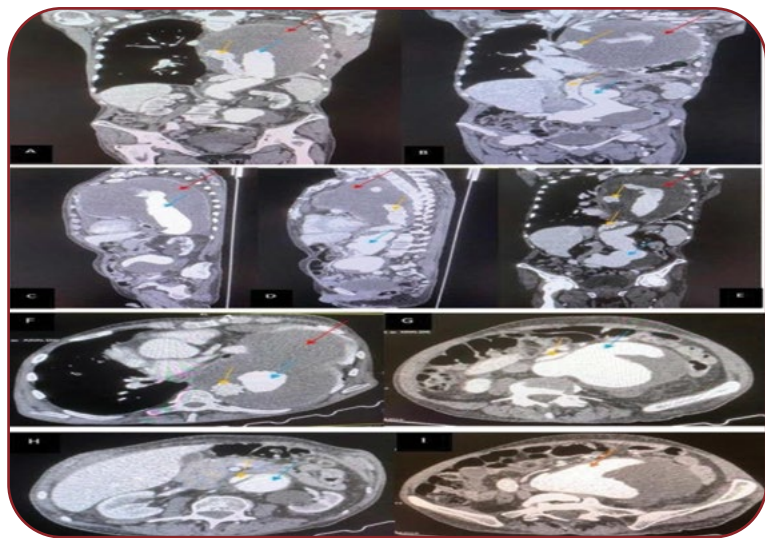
Angio CT aorta: ascending, descending and abdominal aorta – coronary plane (A, B, E); sagittal plane (C, D); axial plane (F, G, H, I). A, B, C, D, E, F (red arrow) massive aneurysm and periaortic hematoma at the level of the aortic arch with extension to the level of the descending thoracic aorta; A, B, D, E, F, G, H (yellow arrow) true aortic lumen; A, B, C, D, E, F, G, H (blue arrow) false lumen; B (green arrow) collapsed left pulmonary parenchyma, remaining; I (orange arrow) partially thrombosed abdominal aortic aneurysm.
